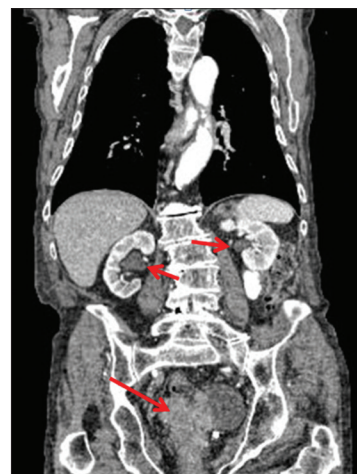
The computed tomography scan of the abdomen revealed bilateral hydronephrosis secondary to solid and extensive bladder tumor. The tumor extends to the posterior and right side of the bladder, seminal vesicles, and prostate gland with lymph nodes in the right external iliac and hypogastric chain of up to 12 mm
